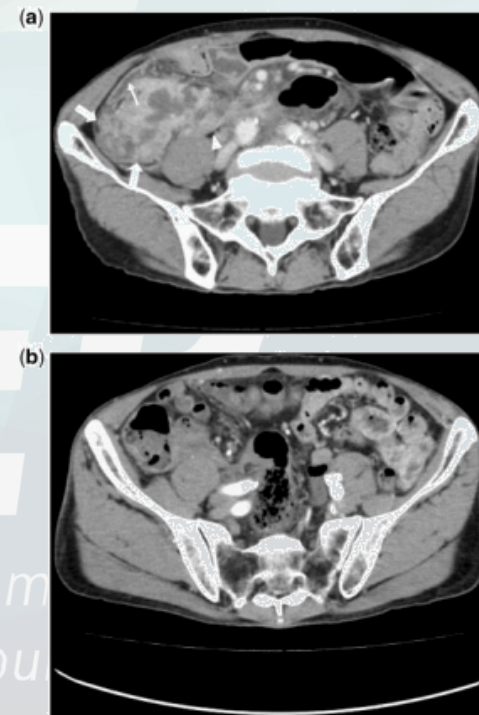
Contrast-enhanced CT. (a) ↑ Wall thickening from the caecum to the ascending colon and ↓ peri-ileocaecal fluid with △ mesenteric lymph node enlargement (on admission). (b) Improving ileocaecitis and shrinkage of the abscess and lymphadenopathy (on the 15th hospital day).
